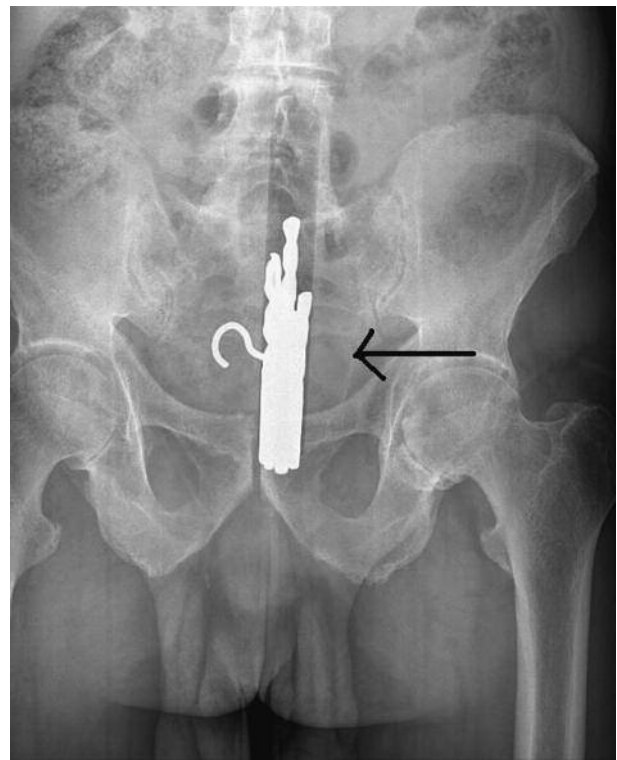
Frontal plain abdomen x-ray view
